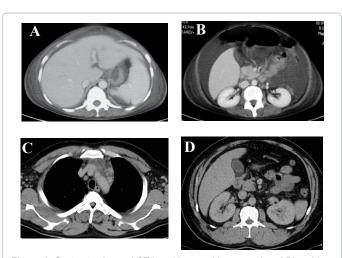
Contrast-enhanced CT in a 47-yeay-old woman (A and B) and in a 39-year-old man (C and D) with TAFRO syndrome. (A): Hepatosplenomegaly and marked subcutaneous edema. (B): Massive ascites and edema, but no para-aortic lymphadenopathy. (C): Bilateral axillary and mediastinal mild lymphadenopathy, anterior mediastinal infiltrative lesion, and subcutaneous edema. (D): Gallbladder wall edema and very mild retroperitoneal lymphadenopathy.
